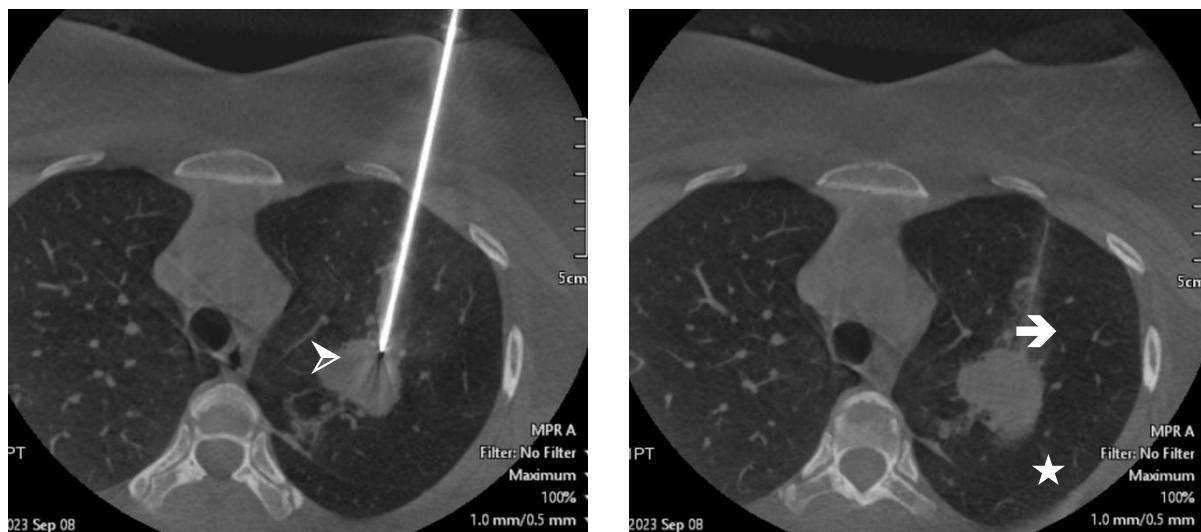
A 37-year-old male with lung mass (Star) in the left upper lobe was requested for tissue biopsy. (a) The coaxial needle (Arrow Head) was inserted under CBCT guidance into the lesion. (b) CBCT performed after removing the coaxial sheath demonstrated the needle track filled to the lung parenchyma with 1 ml normal saline (Arrow). No pneumothorax was
